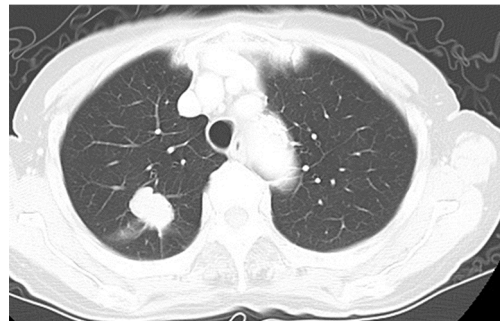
Chest computed tomography (CT) at the time when the patient was referred to our hospital. CT showed a solitary 2.2 cm lung nodule in the right upper lobe.
